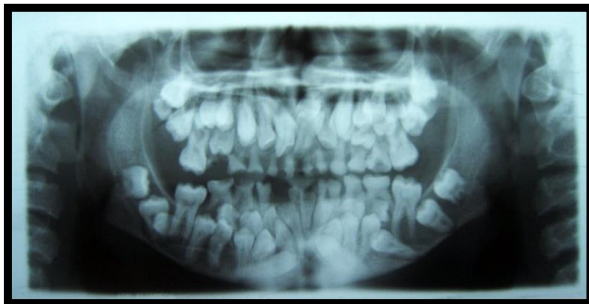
Panoramic radiograph showing multiple impacted and un erupted teeth
